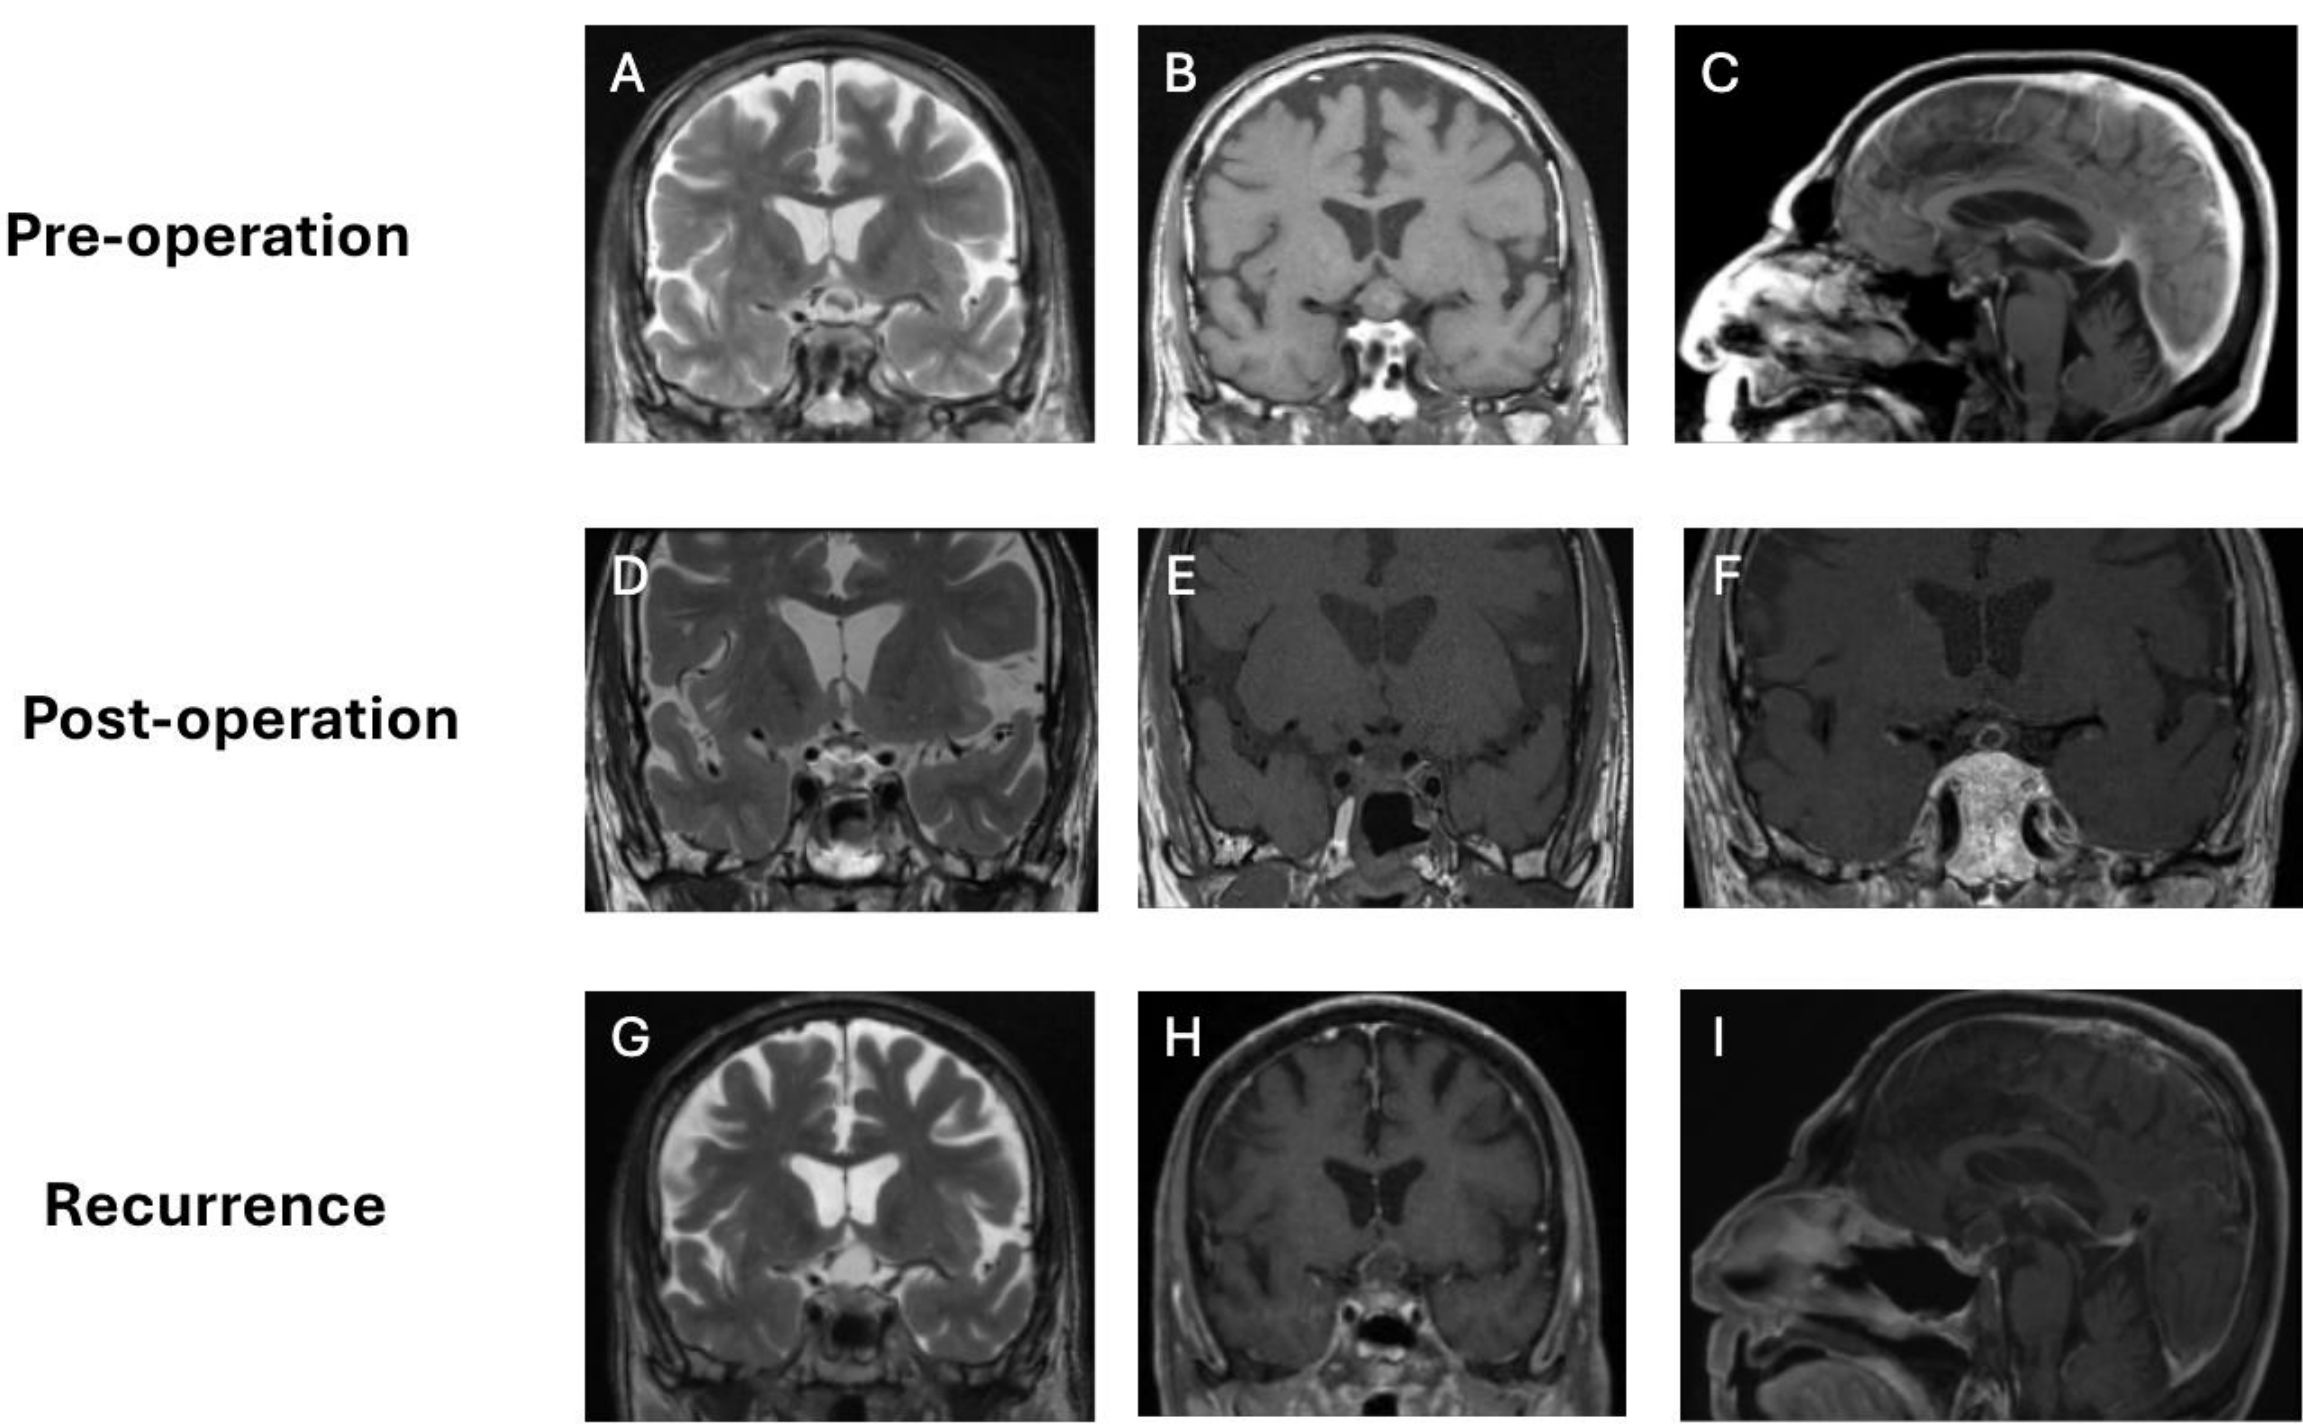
Pre-operative coronal T2 and T1 (A&B), and sagittal (C) CT imaging. Post-operative coronal T1 and T2 (D&E), and T1 post contrast (F) coronal CT. Coronal T1 and T2 (G&H), and post-contrast sagittal views of cyst recurrence.
